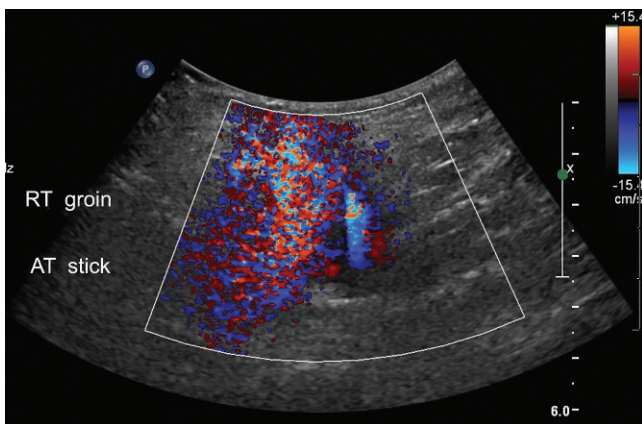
In the right groin, there is a large area of color Doppler that does not conform to a normal vessel. This is perivascular tissue vibration (color bruit) caused by turbulence in the soft tissues caused by a pseudoaneurysm. The vibrations are interpreted as moving blood and improperly color encoded.
